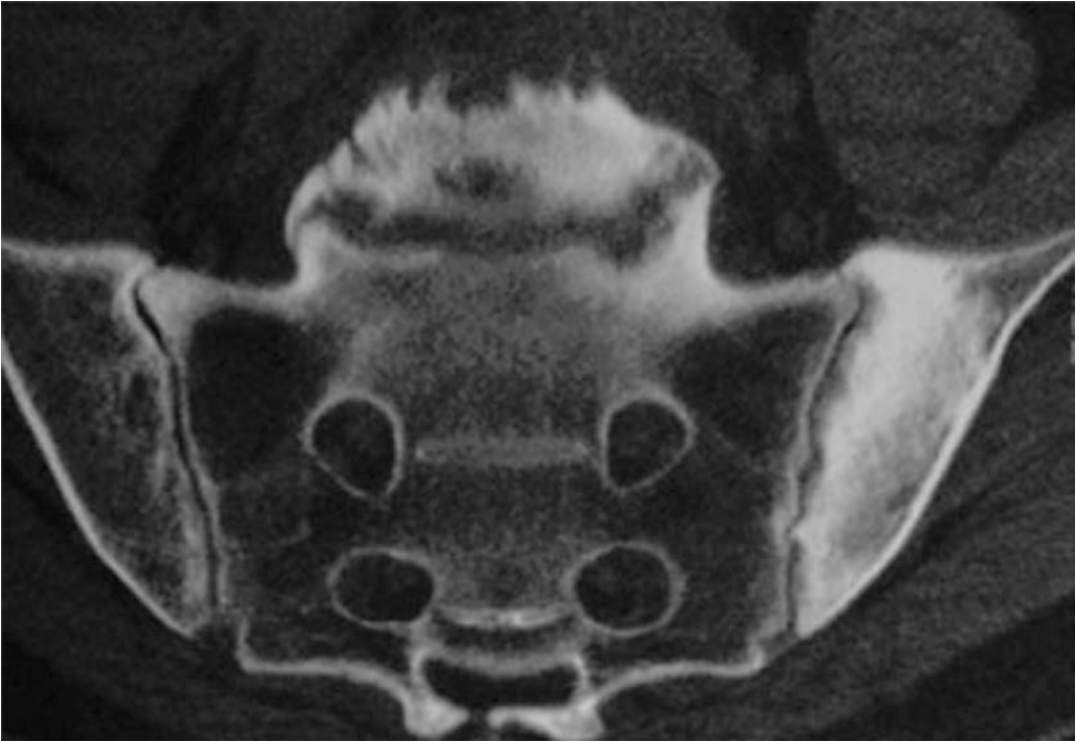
Axial CT of the sacrum demonstrates unilateral sacroiliitis with iliac-sided sclerosis in a patient with SAPHO. (With permission from [10])
